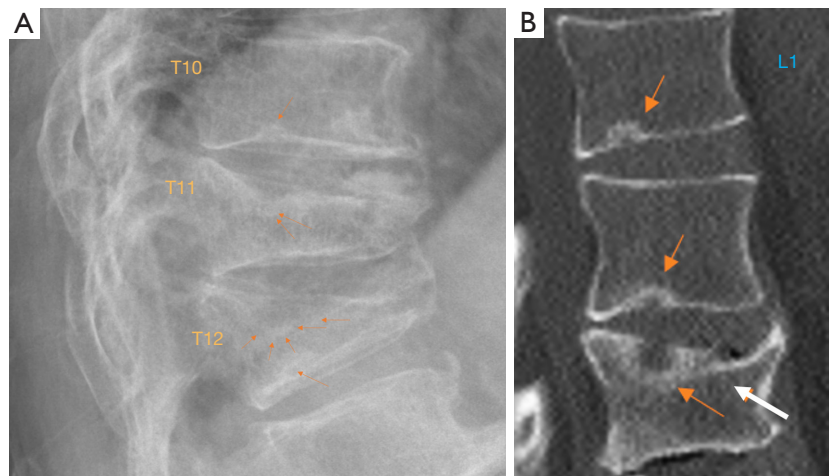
Radiograph of SN (type-2). The bony sclerotic border of these SN is incomplete. Endplate depression is seen in (A) and (B), with hazy increased density surrounding SN reflecting reactive bony regeneration. (C) shows a case of penetrating Schmorl's node (arrow), and the involved vertebral body is collapsed due to osteoporosis. SN, Schmorl's node.
